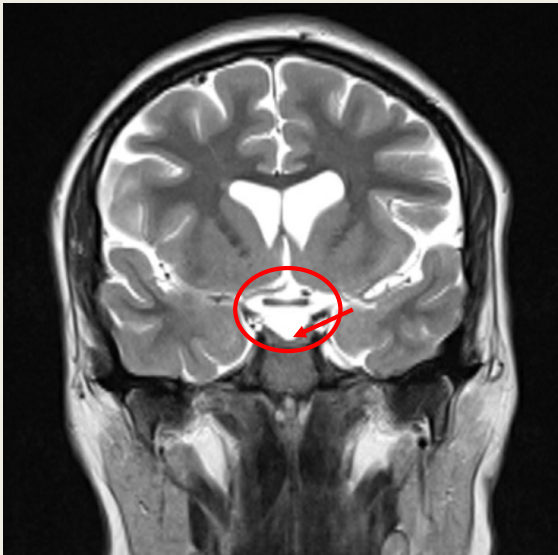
(1) Coronal T2-weighted MRI demonstrating partially empty sella turcica (red circle) and pituitary gland (red arrow); (2) Mid-sagittal T1-weighted MRI demonstrating partially empty sella turcica (red circle) and pituitary gland (red arrow); (3) Axial fluid-attenuated inversion recovery (FLAIR) demonstrating posterior globe flattening (blue arrows) and optic nerve sheath diameter (ONSD) widening (measured 10 mm anterior to optic foramen) – right ONSD 4.8 mm, left ONSD 5.0 mm
